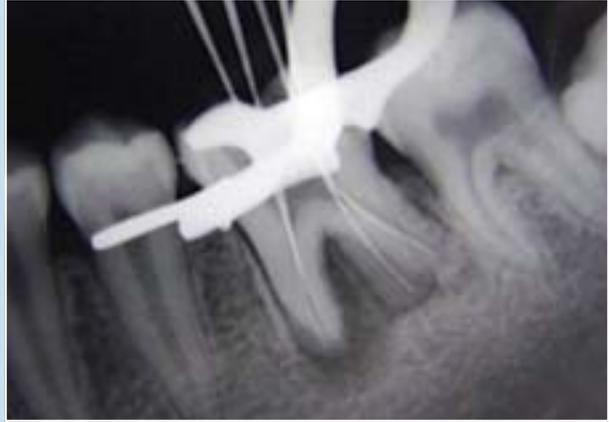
An initial radiograph for working length determination
